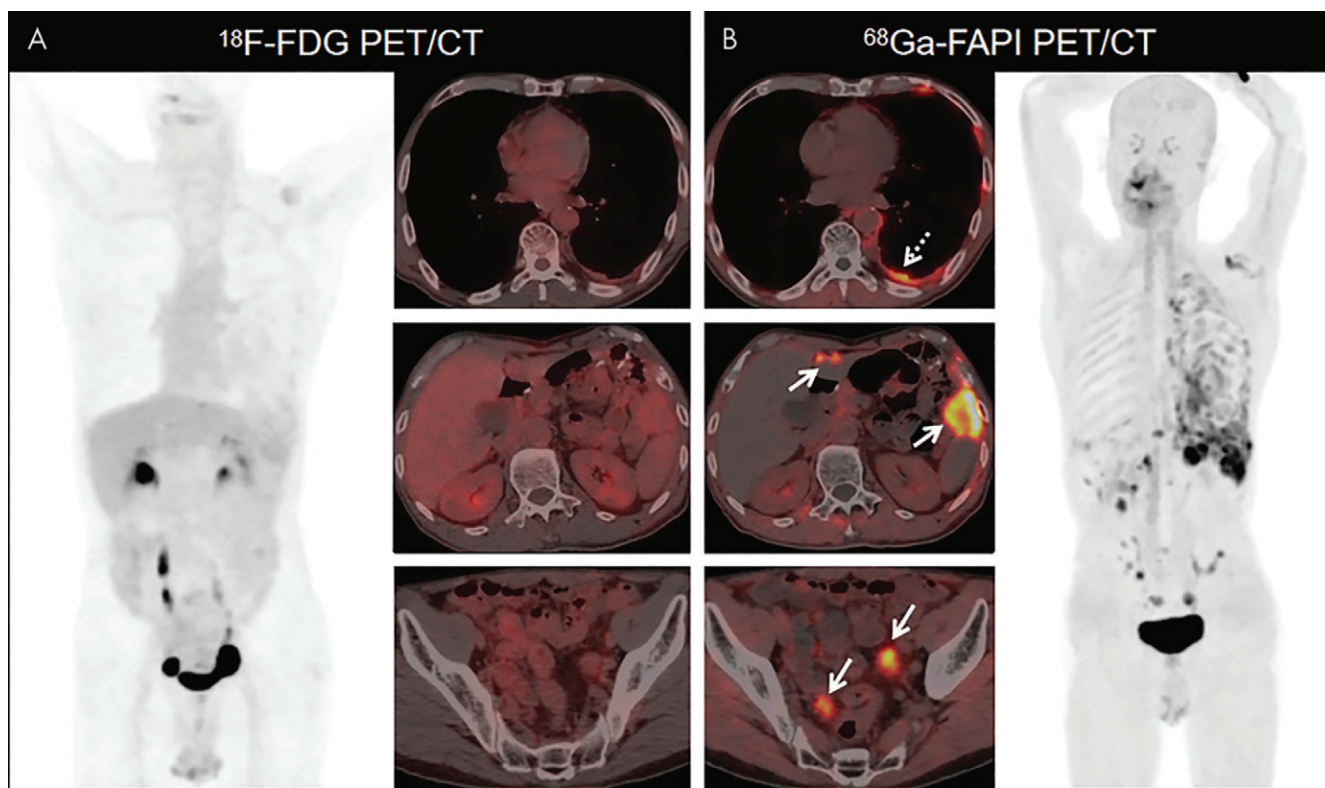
Images in a 66-year-old man who had undergone radical gastrectomy for gastric adenocarcinoma and presented with abdominal pain and rising tumor marker levels. (A) Images from fluorine 18 (¹⁸F) fluorodeoxyglucose (FDG) PET/CT show the thickened pleura and multiple nodules in the peritoneum and mesentery, with low-to-moderate ¹⁸F-FDG activity in these lesions (left image: anterior maximum intensity projection image from ¹⁸F FDG PET; right images: axial fused PET/CT images). (B) Images from gallium 68 (⁶⁸Ga) fibroblast activation protein inhibitor (FAPI) PET/CT show much higher tracer uptake in the thickened pleura (dashed arrow) and peritoneal nodules (solid arrows) (right image: anterior maximum intensity projection image from FAPI PET; left images: axial fused PET/CT images). Subsequent biopsy of pleura and peritoneal nodules revealed metastatic gastric adenocarcinoma (poorly differentiated). (Reprinted, under a CC BY license, from reference 24.)
